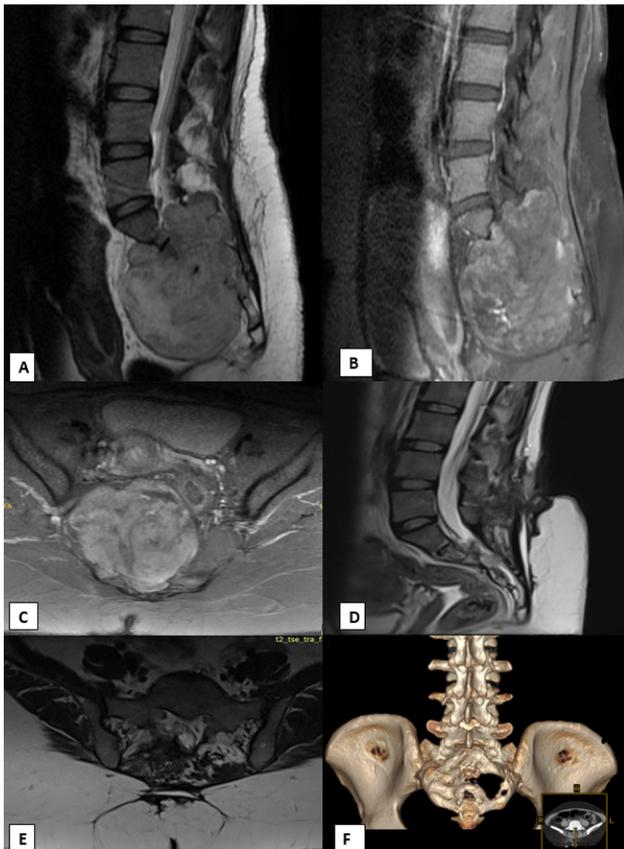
A) Sagittal MRI scan displaying a giant sacral mass in a 34-year-old female patient. The mass appears with heterogeneous intensity on T2-weighted imaging (T2WI). B) Sagittal contrast-enhanced MRI scan revealing the sacral mass. C) Axial contrast-enhanced MRI scan providing an additional view of the sacral mass. D) Postoperative sagittal T2-weighted MRI scan showing the outcome after the excision of the sacral mass. E) Postoperative axial T2-weighted MRI scan displaying the result of the surgical removal of the sacral mass. F) Postoperative 3D computed tomography images of the sacral region, offering a comprehensive visualization of the surgical outcome.
